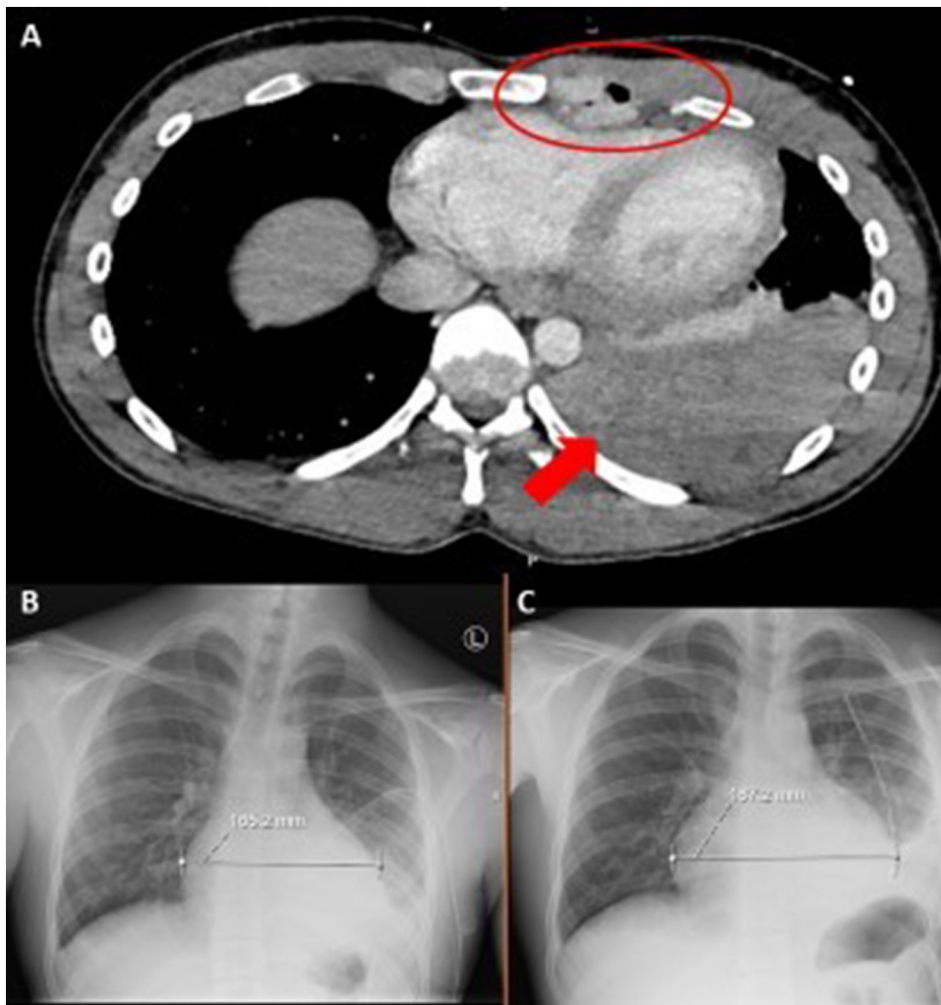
Panel A - CT scan demonstrating, a. large left haemothorax (arrow), and b. left fourth rib fracture and disruption/dislocation of the costal cartilage medially (circled). Panels B and C - chest radiographs taken one week apart showing sizable increase in cardiac contours; A. on admission, B. one week post admission.
